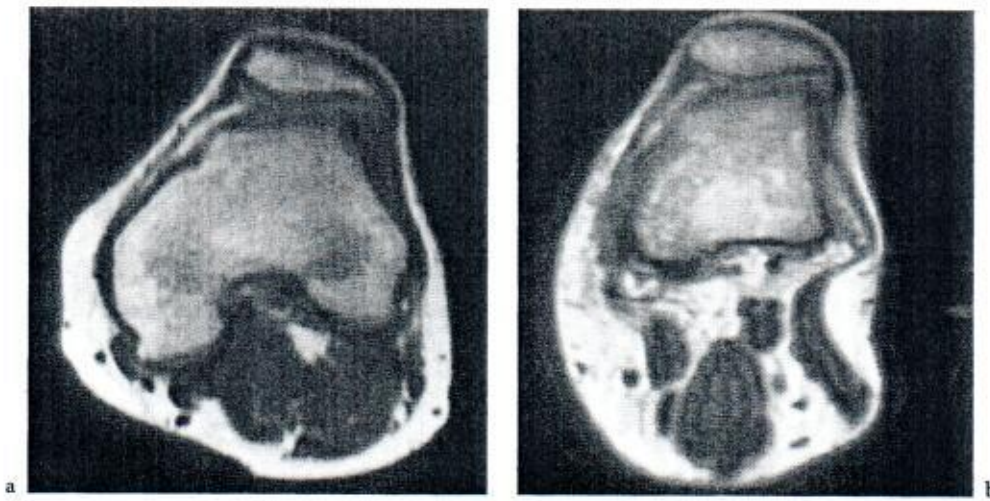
Transaxial MR images of a 28-year-old male with patellar instability, obtained a supine at 10° of knee flexion and b standing, with weight-bearing at extension. The normal lateral patellar displacement in the supine position (a) does not occur in the standing position, even at extension (b)
